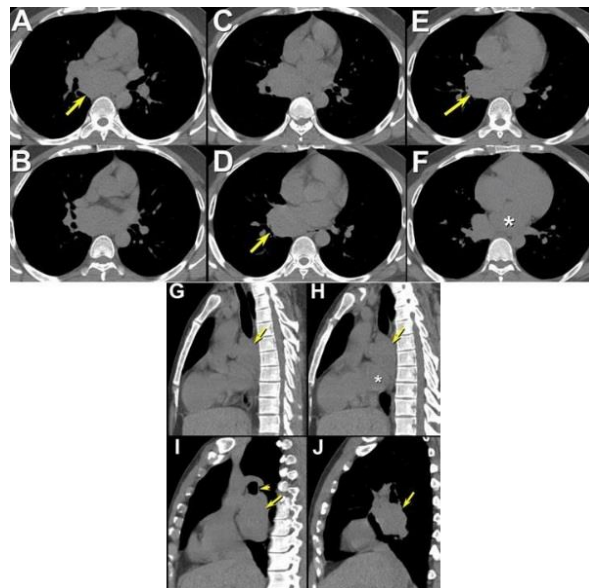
Representative images from unenhanced axial (A-F) and sagittal (G-H) CT.
